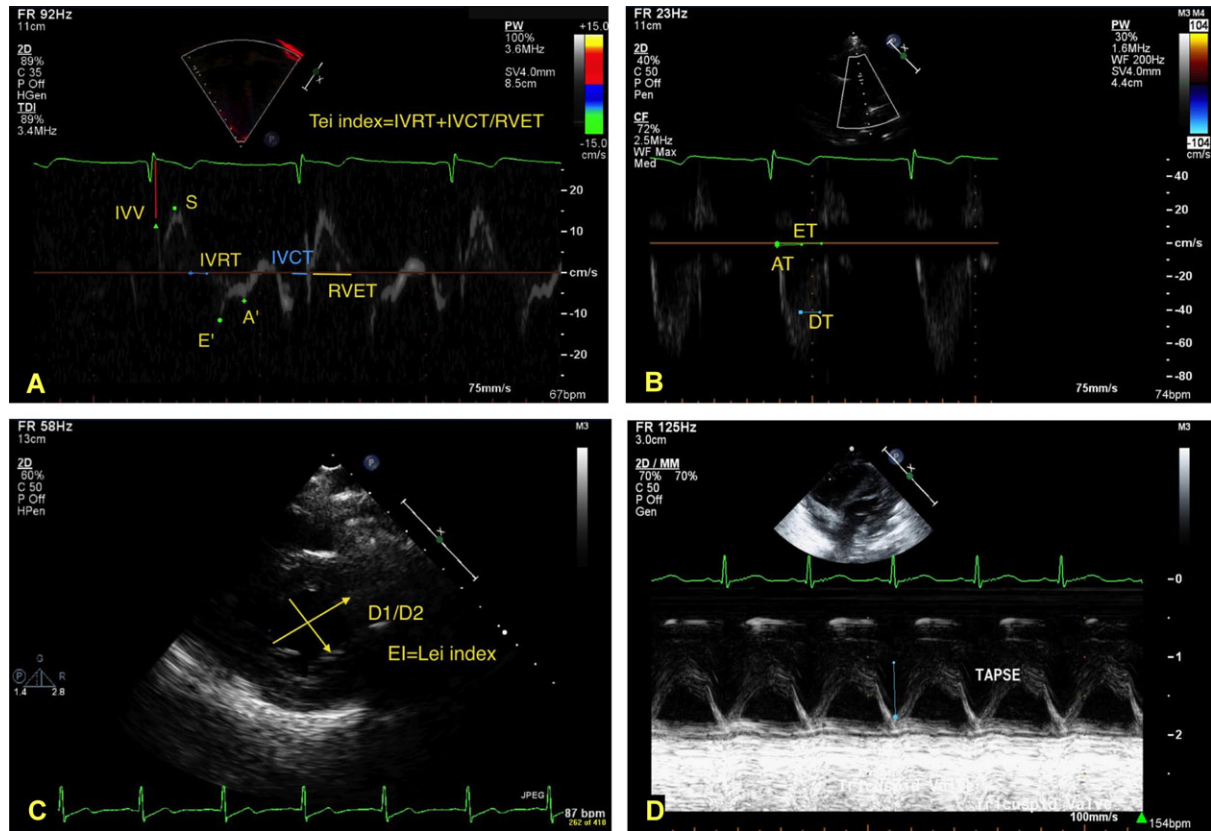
Echocardiography parameters used for assessment of pulmonary hypertension. A. TDI and Tei index calculation. B. Pulmonary artery flow analysis. C. Eccentricity index calculation (Leis index). D. Measurement of TAPSE.
